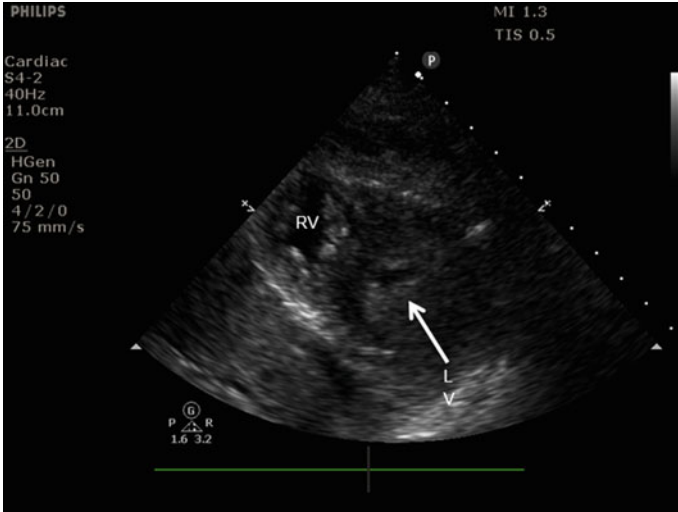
End systolic parasternal SAX view showing an obliterated LV cavity in a patient with hypovolemia. This patient also has significant left ventricular hypertrophy (LVH). *RV* right ventricle; *LV* left ventricle
